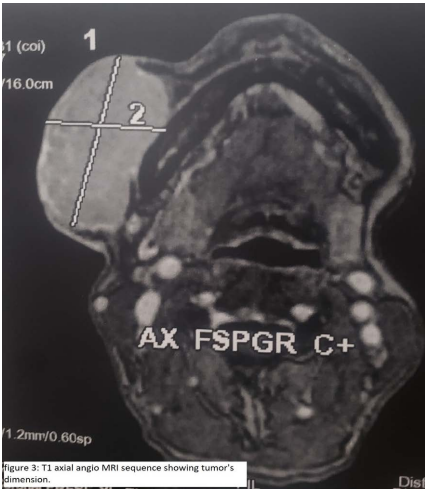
T1 axial angio MRI sequence showing tumor's dimension.
